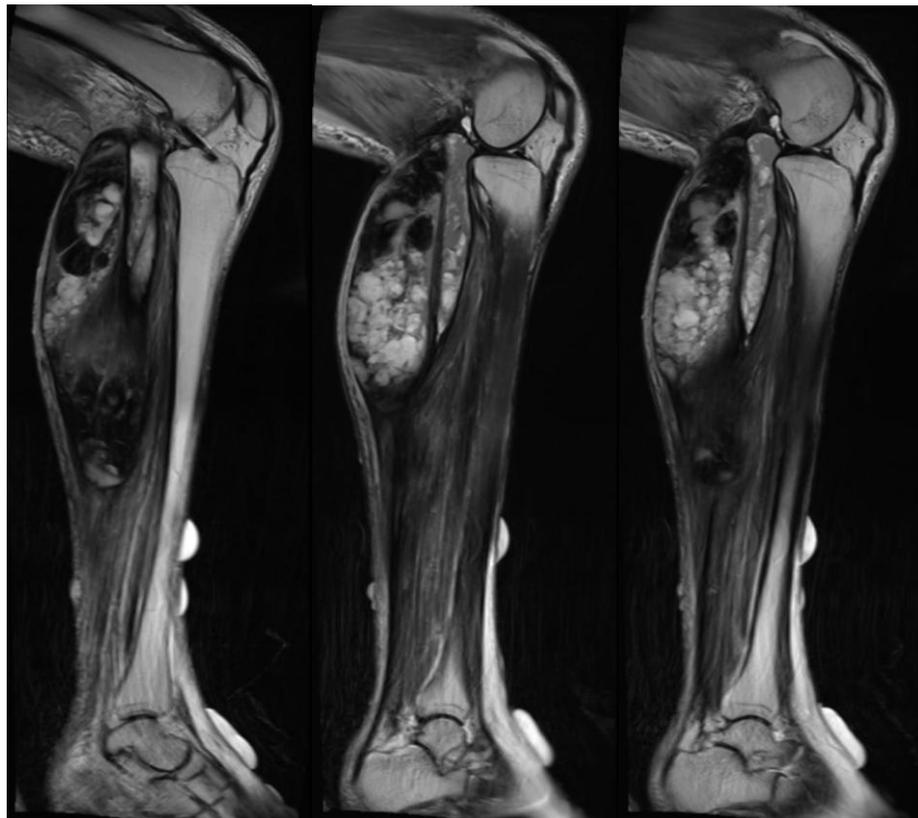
MRI left leg T2W sagittal view.
